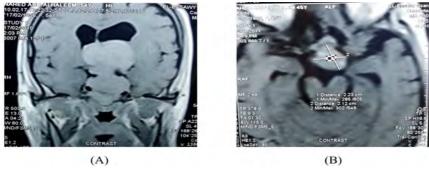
A- Preoperative MRI; esthioneuroblastoma, B- Total resection of the tumor.
